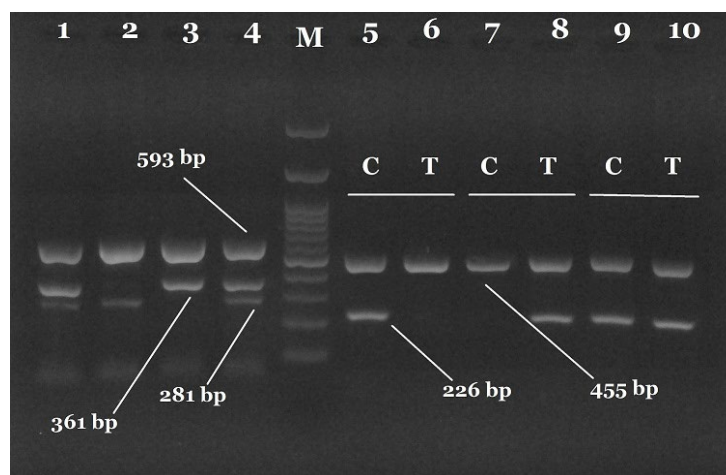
Agarose gel electrophoresis results for genotyping A1298C and C677T variants: Lane M: 100 bp DNA ladder. A1298C (lanes 1–4): Lane 1 and 4, heterozygous genotype (AC; bands at 281 bp, 361 bp, and 593 bp as internal control); Lane 2, homozygous wild-type (AA; bands at 281 bp and 593 bp); Lane 3, homozygous mutant (CC; bands at 361 bp and 593 bp). C677T (lanes 5–10): Lane 5–6, homozygous wild-type (CC; bands at 226 bp and 455 bp as internal control); Lane 7–8, homozygous mutant (TT; bands at 226 bp and 455 bp); Lane 9–10, heterozygous (CT; bands at 226 bp, 455 bp, and internal control)
